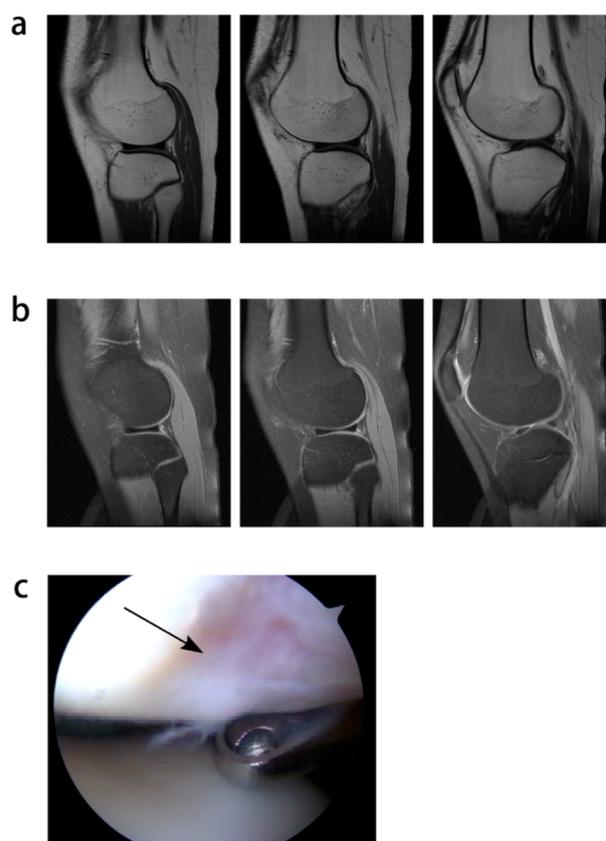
MR images and arthroscopic images of patient number 2. (a) T_1 -weighted MR image of the external condyle of the femur shows no damage to cartilage. (b) T_2 -weighted MR image of the external condyle of the femur shows no damage to cartilage. (c) Arthroscopic images of the external condyle of the femur shows second-degree cartilage damage (cartilage damage area was marked by black arrow).
